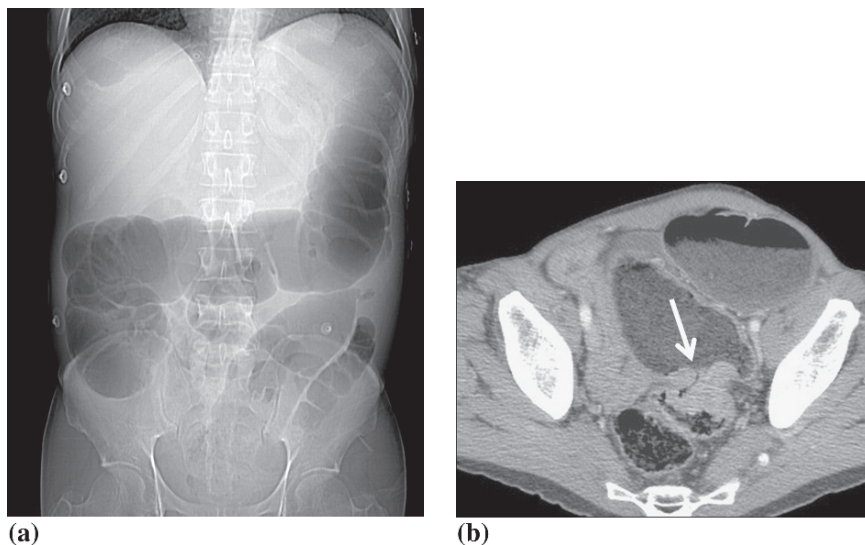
Large bowel obstruction caused by colon cancer. The scout topogram (a) shows marked dilatation of the colon, with little or no gas in the rectum. Axial CT image of the pelvis demonstrates the annular obstructing sigmoid mass (arrow), as well as marked dilatation and retention of gas and fluid in the segments proximal to the mass
